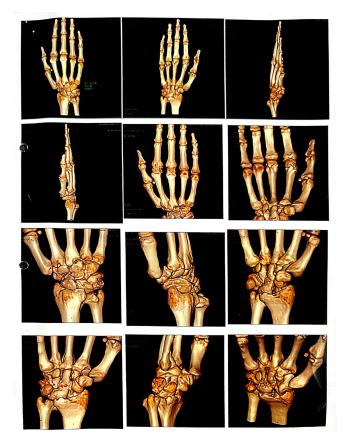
CT scan of right wrist
